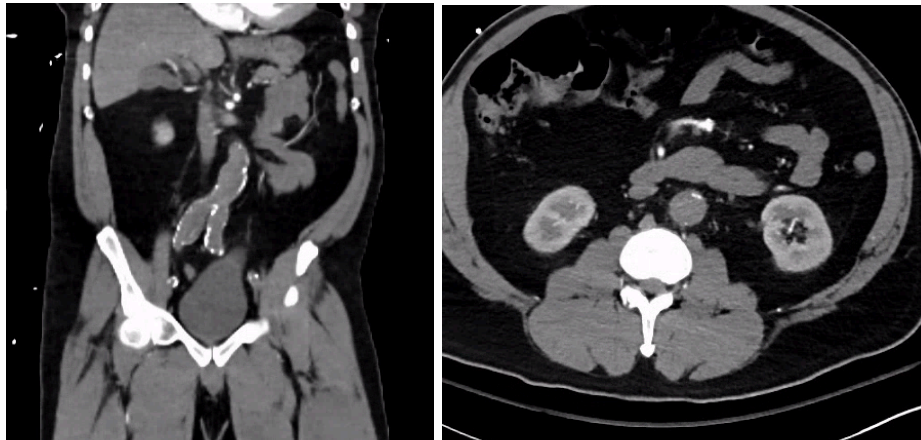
Coronal CTA abdomen showing complete aortoiliac occlusion and associated fusiform aneurysmal dilations
